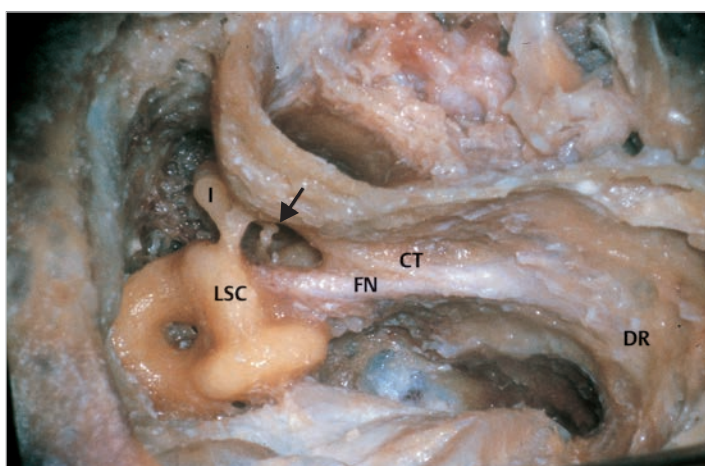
Bone around the posterior labyrinth is removed, the mastoid segment of the facial nerve is exposed, and the dura of the posterior fossa is uncovered. Note that the facial nerve runs just anterior to the digastric ridge, and just inferomedial to the lateral semicircular canal. CT, chorda tympani; DR, digastric ridge; FN, facial nerve; I, incus; LSC, lateral semicircular canal.
